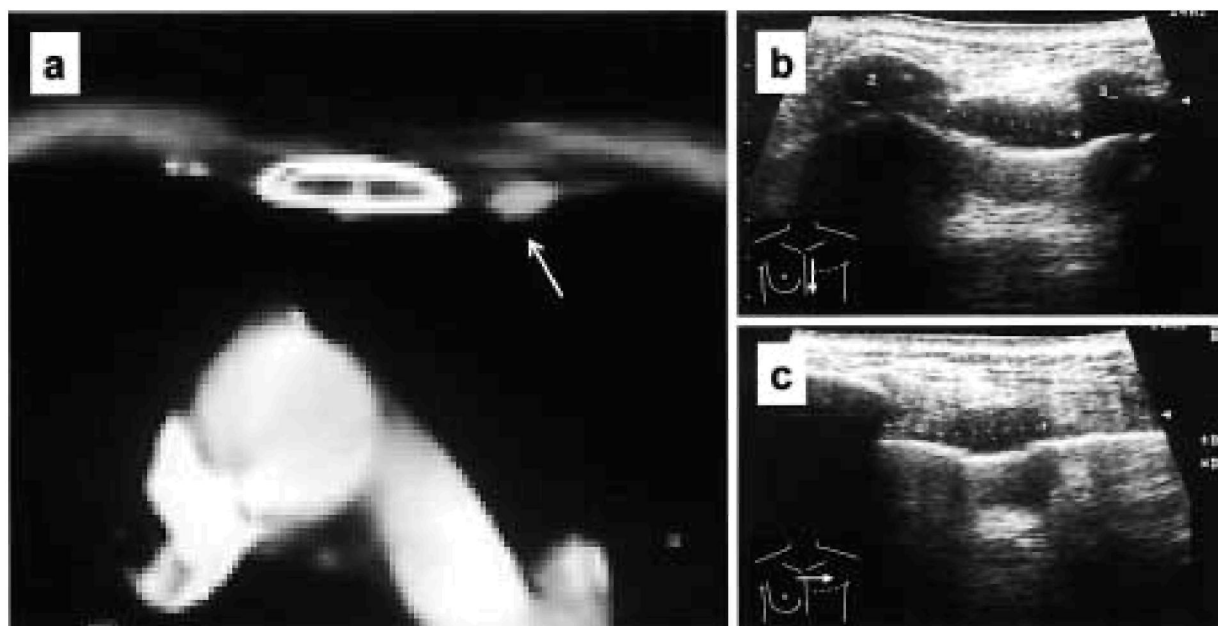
Internal mammary node was detected by CT (a) and US (b: sagittal scan, c: transverse scan) on the 2nd intercostal space (Case 3).
